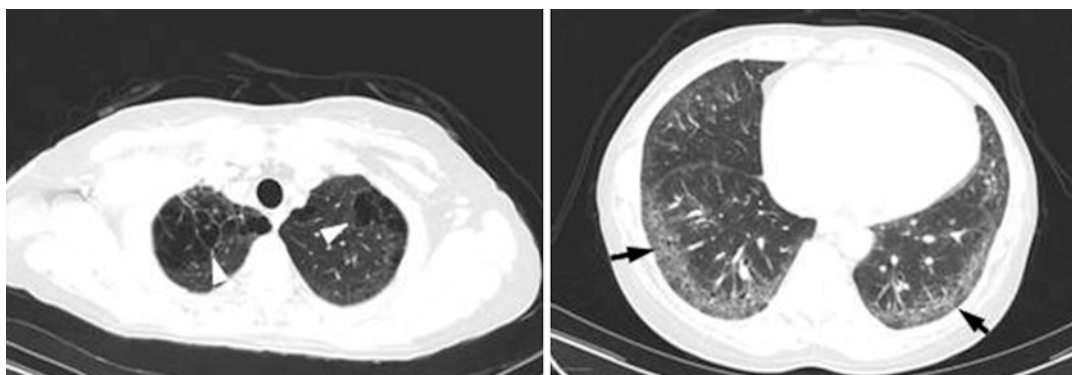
Chest CT findings of combined pulmonary fibrosis and emphysema. At *left*, upper lobe emphysema is noted by white arrowheads. At *right*, peripheral reticular opacities are denoted in the lung bases by *black arrows*
